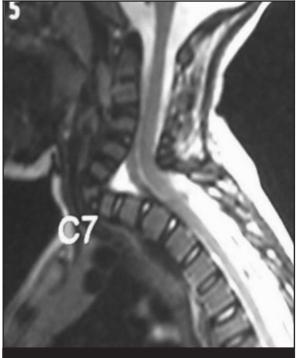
MRI scans showing the widening of the canal
